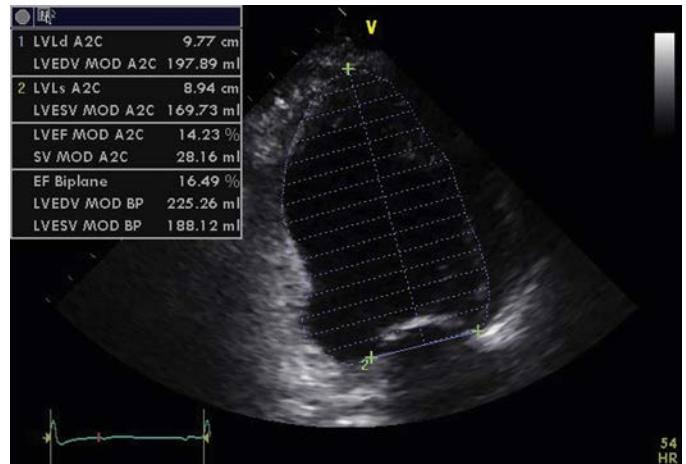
Evaluation of left ventricular (LV) volumes and systolic function using the Simpson's method of disks. The LV endocardial borders are traced at end systole and end diastole in two orthogonal views, the apical four- and two-chamber views, and the LV ejection fraction (LVEF) is derived.
